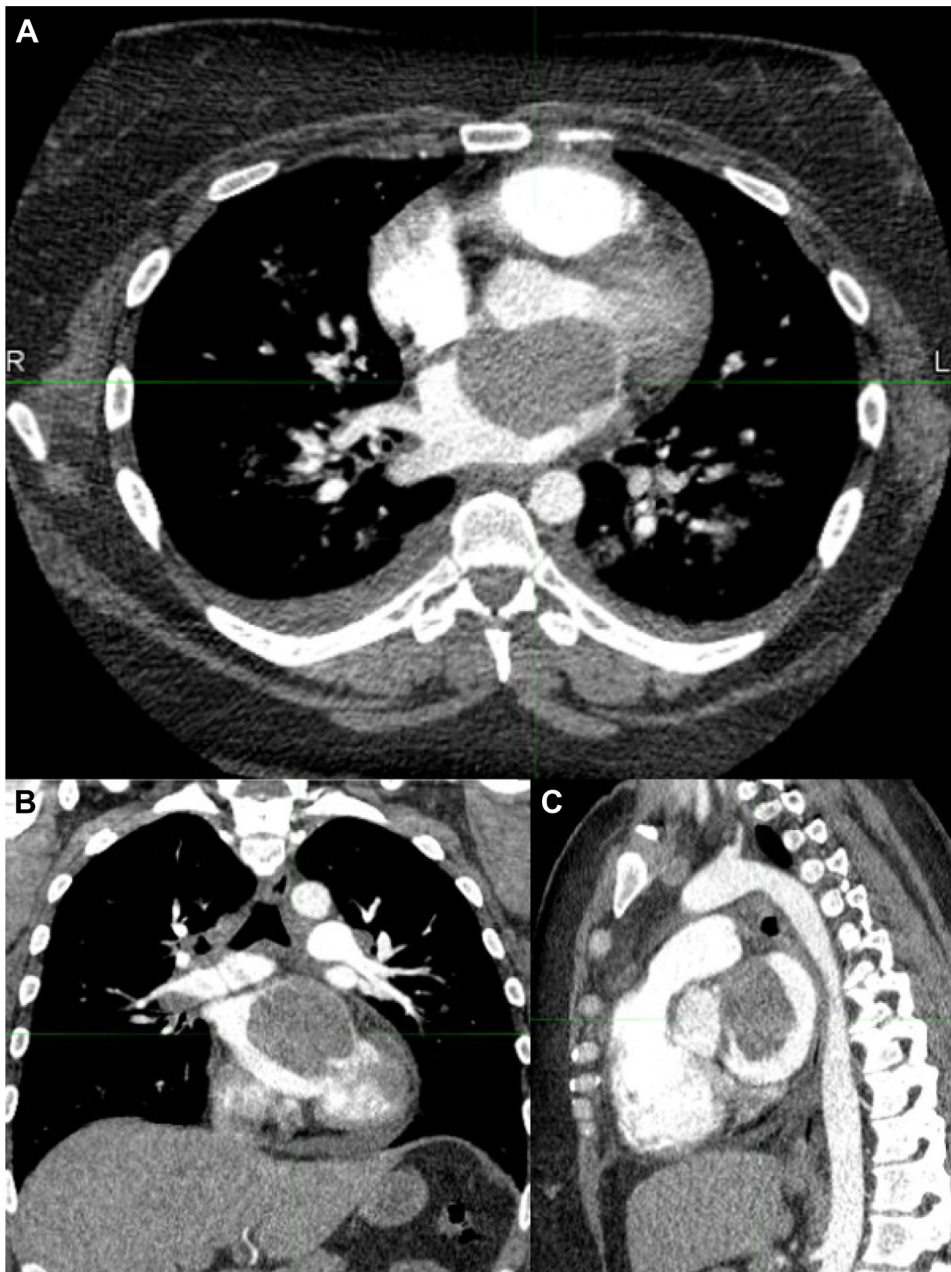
Computed tomography angiography chest imaging at diagnosis, before any therapy in axial (A), coronal (B), and sagittal (C) slices.
